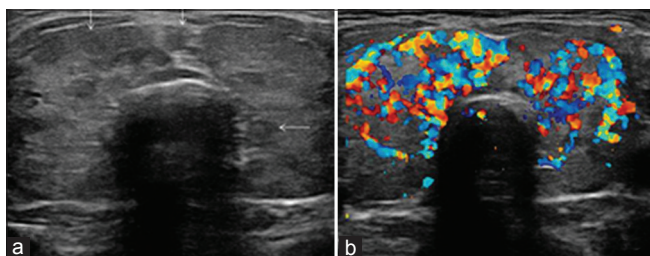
Focal Hashimoto's thyroiditis in a 35-year-old female patient, who presented with features of hypothyroidism and had anti-thyroid antibodies positive for the disease. Transverse gray-scale ultrasound neck (a) demonstrates ill-defined heterogeneous hypoechoic areas localized to postero-inferior aspect of thyroid lobes bilaterally (arrows). Longitudinal scan (b) left lobe thyroid (of same patient) clearly depicts the abnormal area which also shows increased vascularity on color Doppler sonogram (c)
